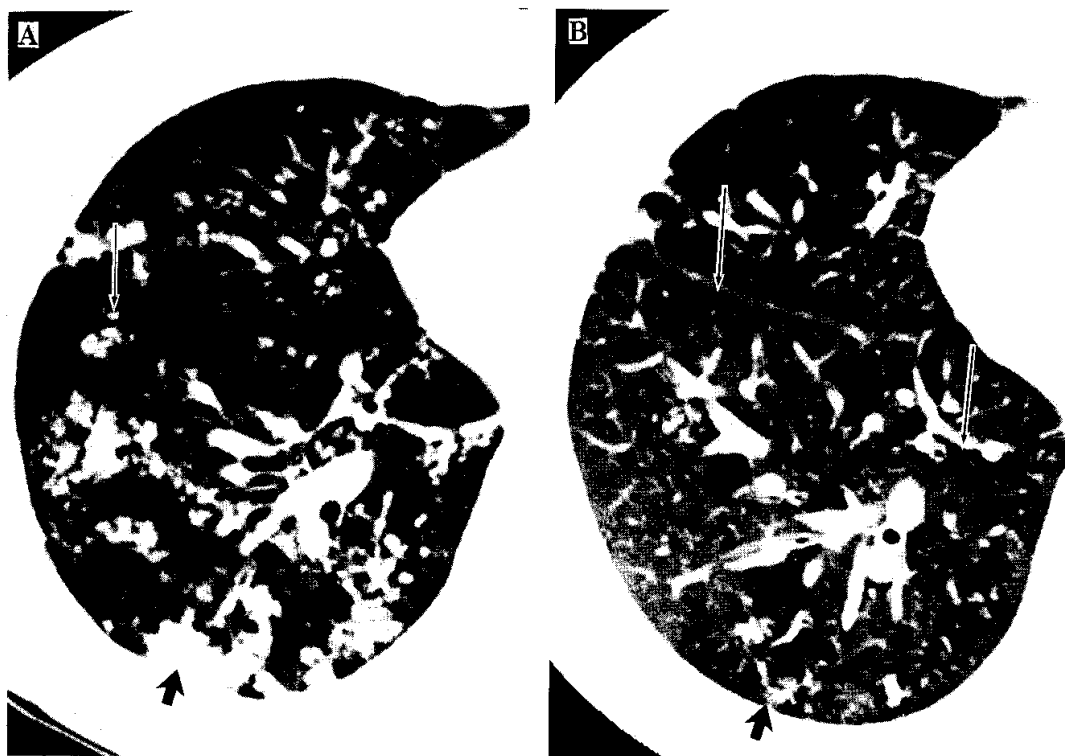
High-resolution CT from a woman aged 20 years with extensive bronchogenic spread tuberculosis obtained at the time of diagnosis (A), and after 9 months' of antituberculous chemotherapy (B), at the same level.
